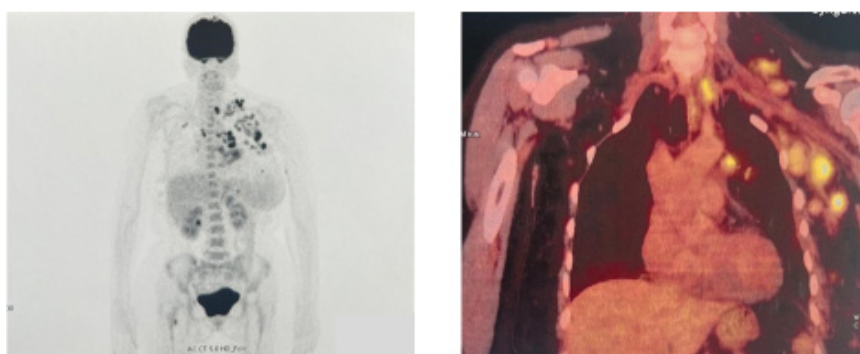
TEP/CT axial slide, hypermetabolism on the left pectoral muscle SUVmax 6.5, with hypermetabolism on the left mammary skin SUVmax 3.1, with a left axillary adenopathy SUVmax 11.7.
